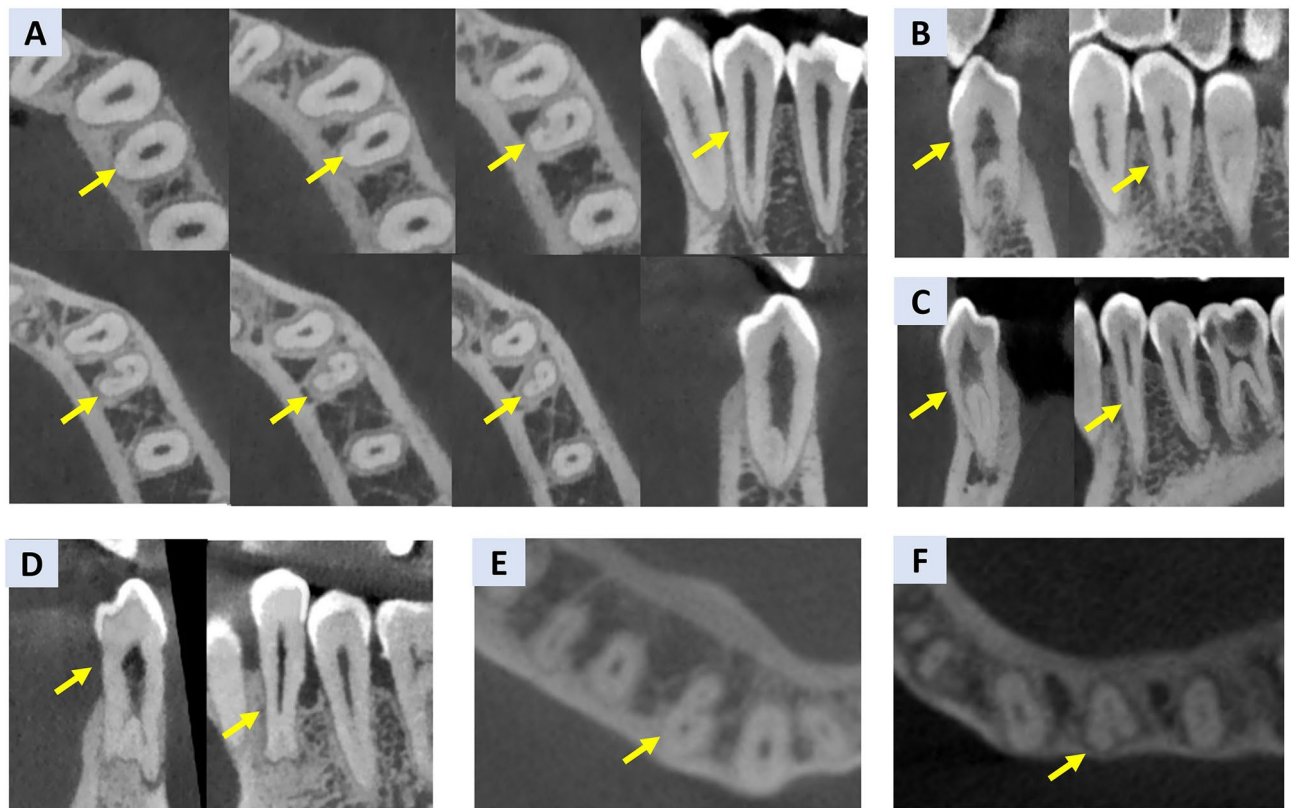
Representative CBCT images of mandibular first premolars showing various root and canal morphologies. (A) Serial axial and sagittal images from a single tooth with a C-shaped canal at different root levels. (B–D) Sagittal and coronal views of taurodontism types: (B) mesiotauroidontism, (C) hypotauroidontism, and (D) hypertauroidontism, with varying pulp chamber elongation and apical floor displacement. (E) Axial view with a distinct mesial root groove. (F) Axial view showing a buccal groove. Yellow arrows highlight the relevant anatomical variations.
